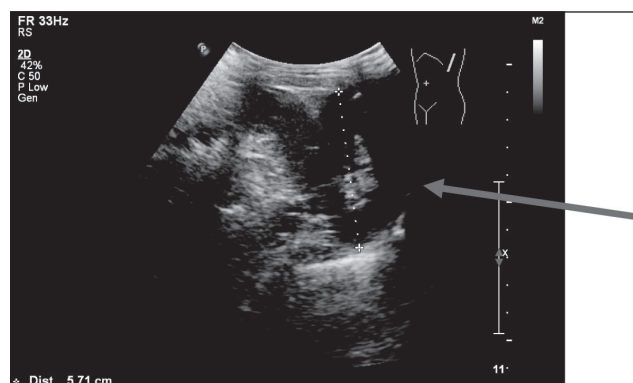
Ultrasonography of the chest; arrows shows thoracic ectopic kidney.
